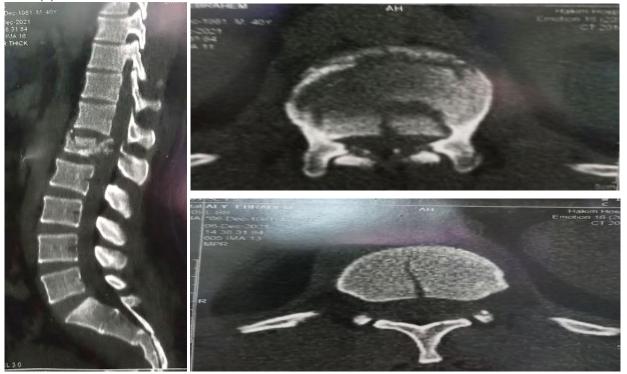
Preoperative CT of L.S, Axial and sagittal views, reveal Burst Fracture of L1 body, with retro pulsed bone fragment leading to canal stenosis.
